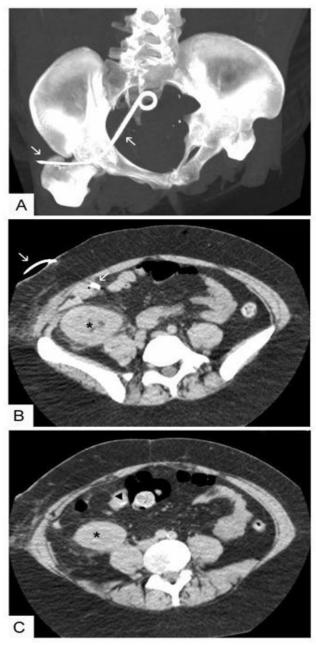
CT imaging with digital reconstruction showing the course of the nephrostomy catheter (A) and its unexpected position (B and C; arrows) far away from the renal allograft (asterisk) and its tip likely adherent to or within the ileum (arrowhead).
